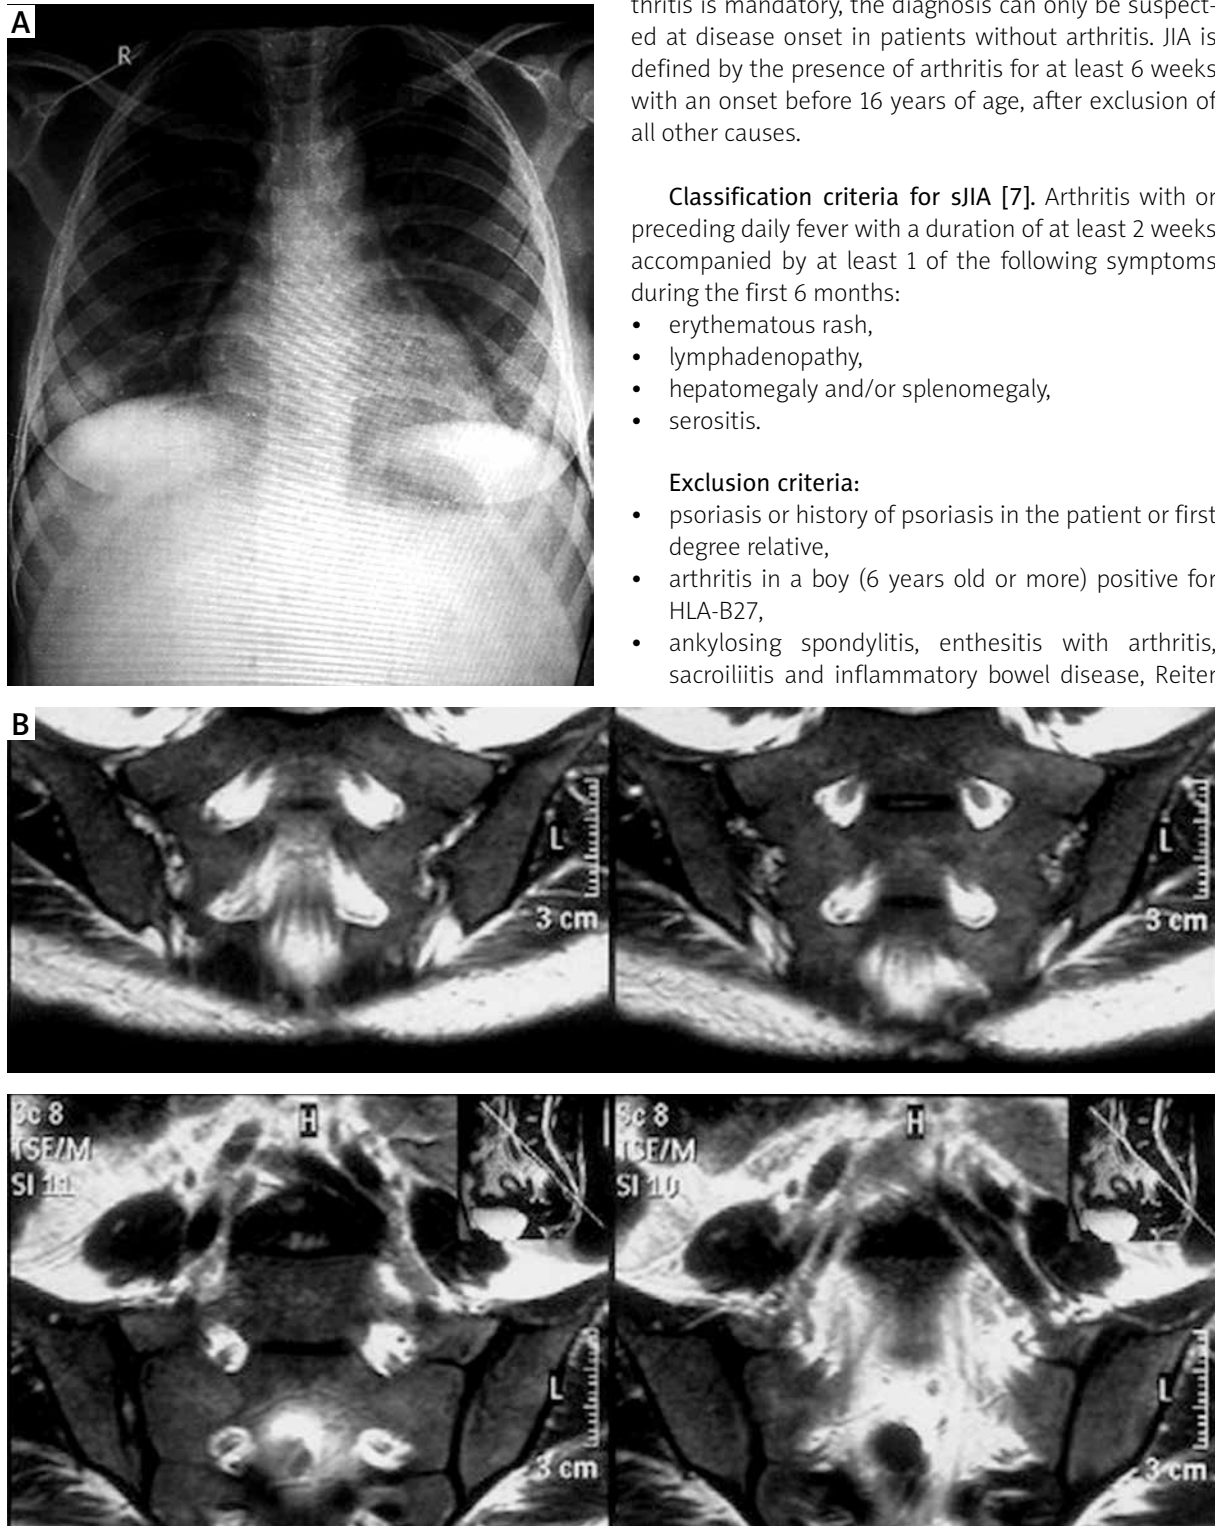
Chest X-ray of the patient, which was normal (A). MRI of sacro-iliac spine, which was normal (B).
